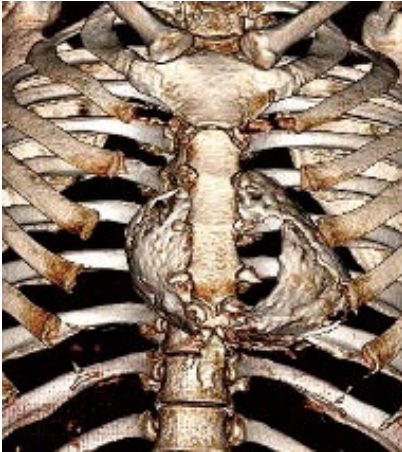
Pre-operative non-contrast computed tomography reconstructed volume rendered image shows pericardial "eggshell" calcification around the heart.
